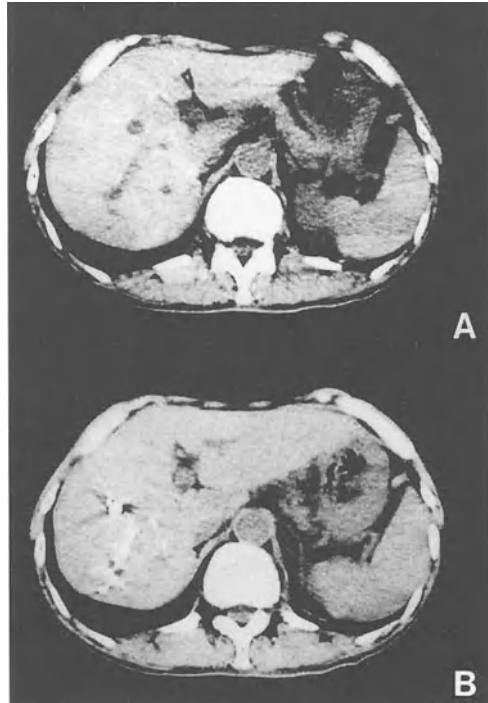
A, B. Computed tomograms before (A) 2 weeks after (B) portal vein embolization (PVE). The left lobe is larger than before
